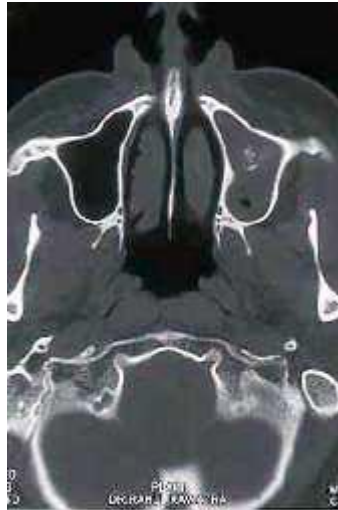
Computed Tomography (CT Scan) showing opacification of the left maxillary sinus.
